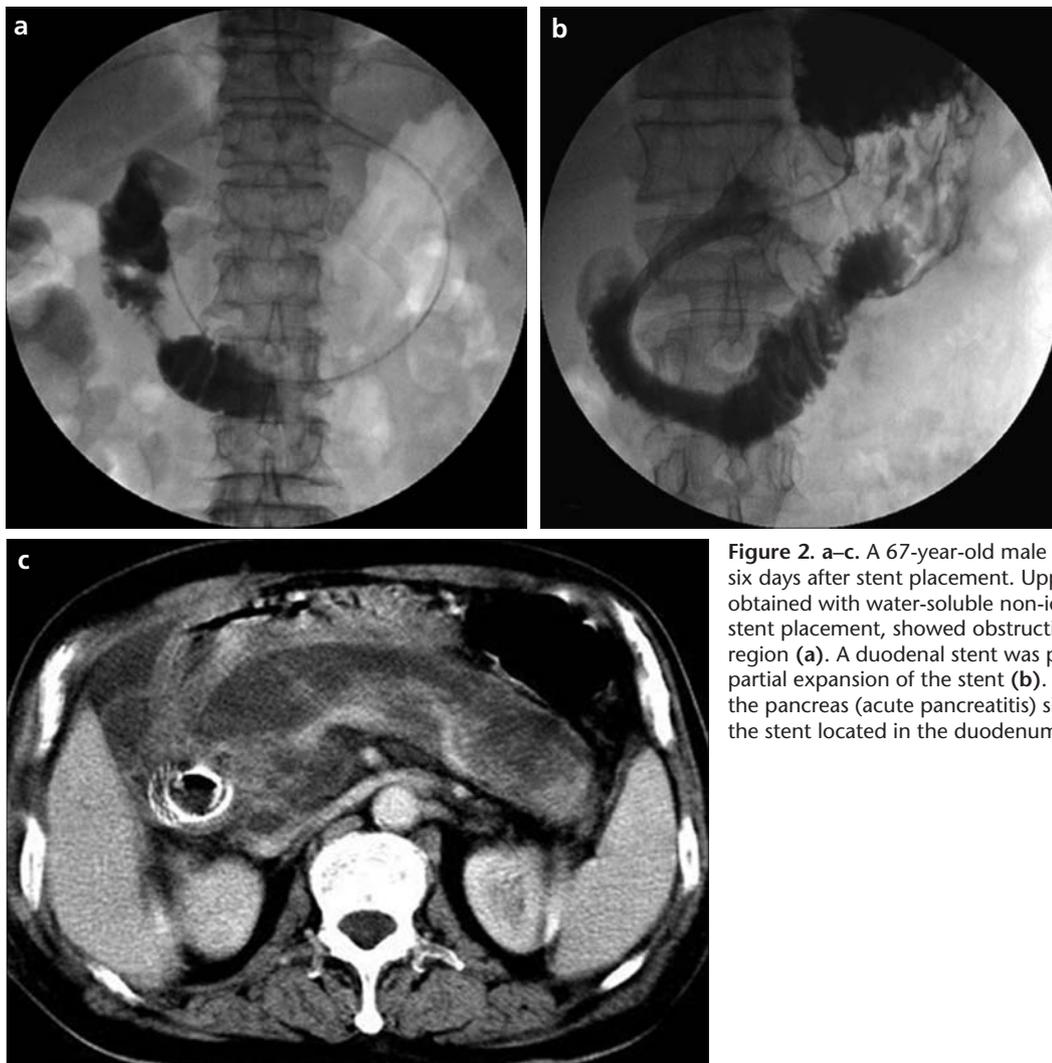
a–c. A 67-year-old male patient with acute pancreatitis at six days after stent placement. Upper gastrointestinal radiography, obtained with water-soluble non-ionic contrast medium before stent placement, showed obstruction at the level of the duodenal region (a). A duodenal stent was placed at the stricture area with partial expansion of the stent (b). CT demonstrated enlargement of the pancreas (acute pancreatitis) six days after the procedure, with the stent located in the duodenum (c).
